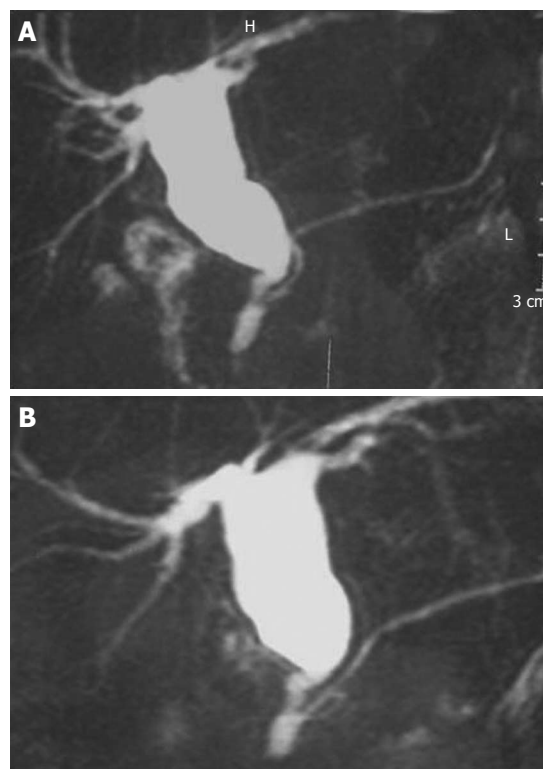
Magnetic resonance imaging. A: Pancreaticobiliary maljunction variety I of Kimura; B: Pancreaticobiliary maljunction with cystic dilatation of common bile duct (Type I of Todani).
